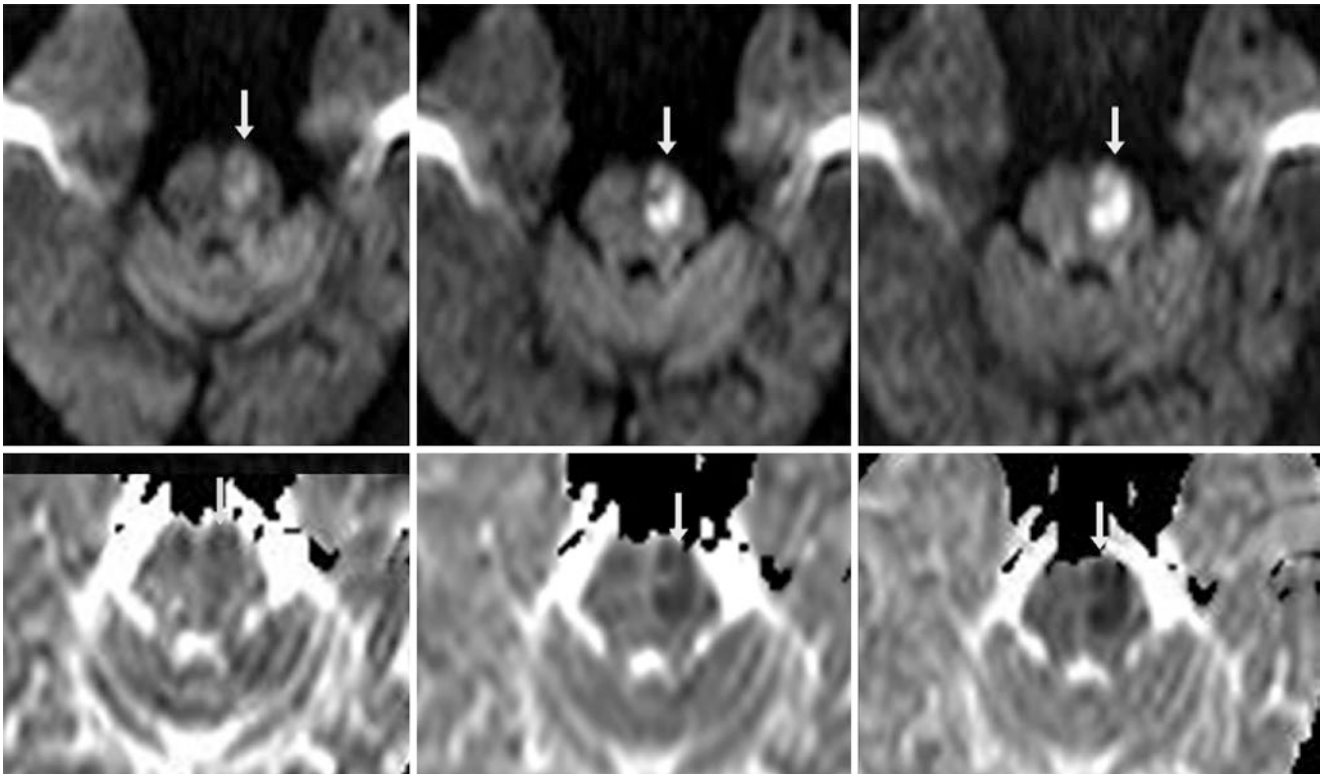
Comparison case of brainstem infarct. A 66-year-old had a left-sided brainstem infarct (arrows) on a 1.5 T MRI, which is not well visualized on $b=1000$ DWI (top left) or ADC map (bottom left), but is better visualized on DWI at $b=1500$ (top middle) with its ADC map
